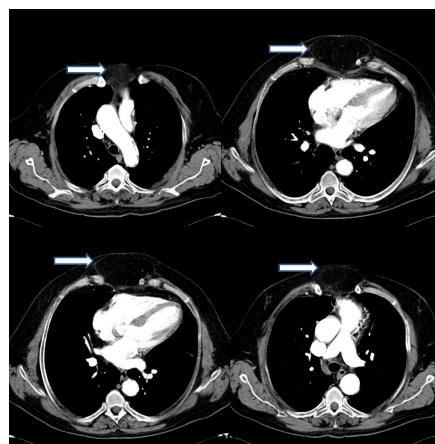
CT scan of the thorax: There is a large protrusion of the heart through the sternum after CABG (arrows).
